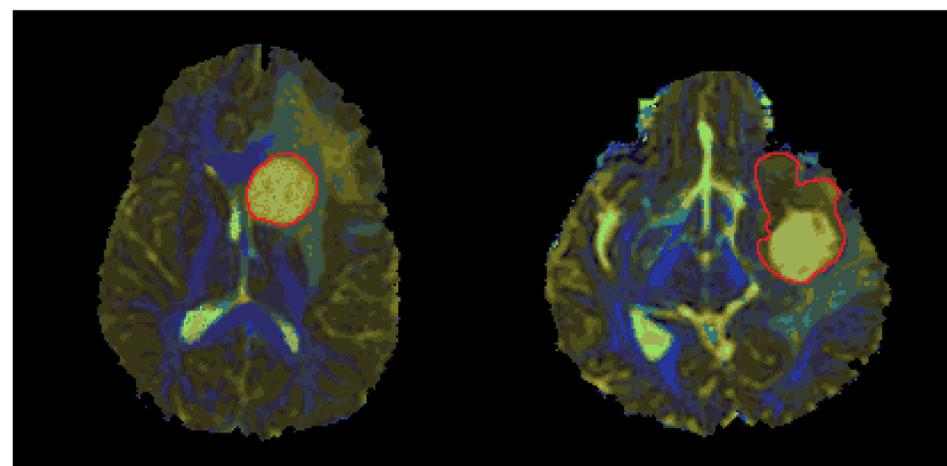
Whole brain segmented maps of a LGG (left) and a HGG (right) case, resulting from the k-medians clustering of the DTI isotropic, anisotropic and T2-weighted components feature space. The different colors presented (k=16) correspond to distinct brain tissue diffusion properties, which facilitate the precise definition of healthy tissue, tumor core and peritumoral edema. The final delineation of tumor core (red outline) is the outcome of the further combination with T1-weighted post-contrast imaging.
